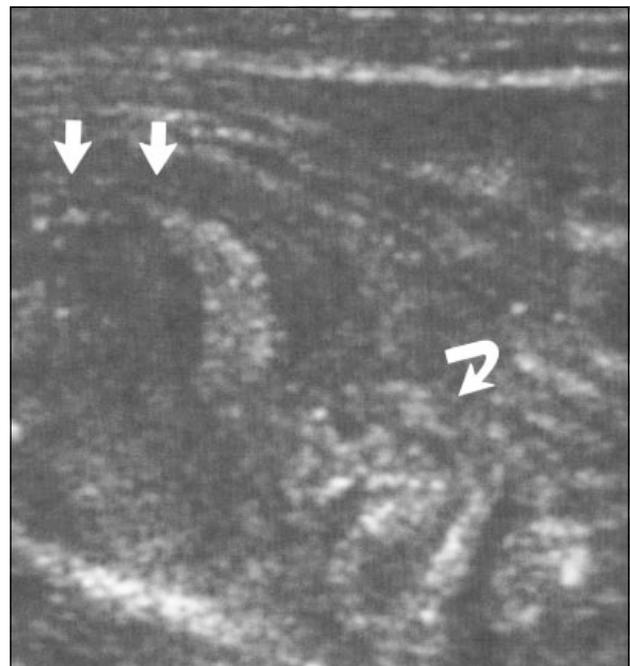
A 17-year-old boy (patient 17) who presented with a 3-day history of right lower quadrant pain. Axial section through inflamed terminal ileum (curved arrow) and inflamed caecum (straight arrows), revealed loss of architecture and large, non-compressible, anechoic centre in caecum. Note anechoic thickening along the walls of the terminal ileum and caecum. Real time scanning showed scarce passage of bowel contents through the lumen. Colour Doppler scan demonstrated hyperaemia of the bowel indicating active disease (not shown).
